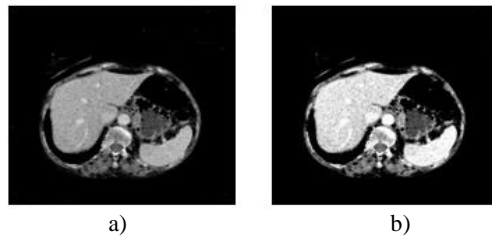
Pre-processed CT image: a) eroded image, b) enhanced image.
